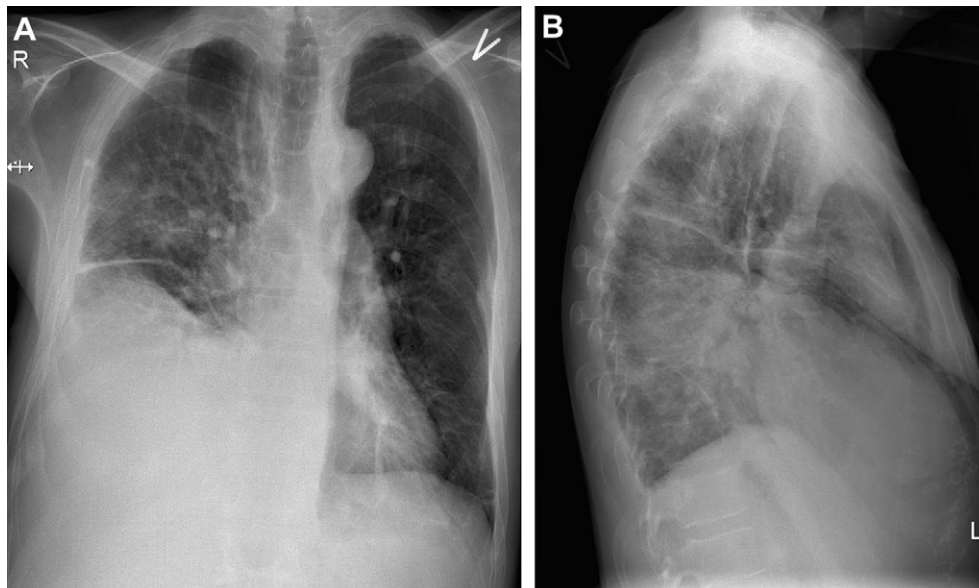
1A and 1B. Chest X-ray (frontal and lateral view) taken at time of primary admission showing right-sided basal infiltrate and pleural effusion.
